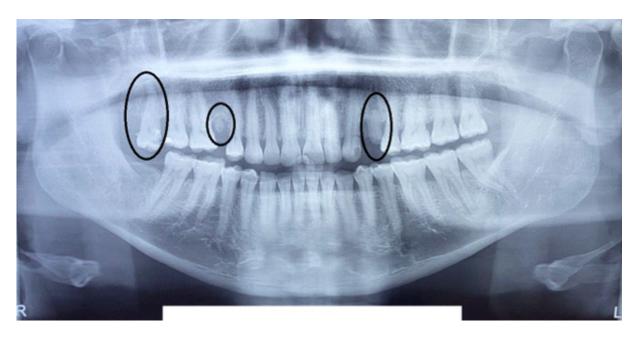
Radiographic exam (panoramic) showing residual roots 15 and 24 and thickening of the periodontal space of tooth 18, as well as a carious lesion.
